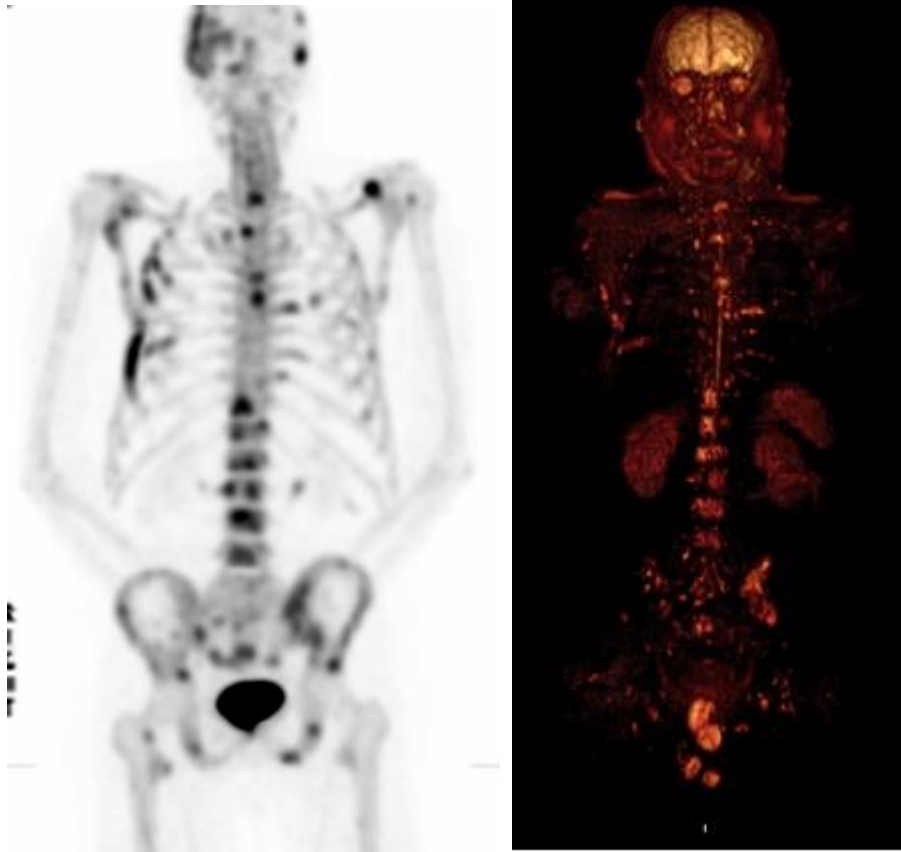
(Left) ^{18}NaF -PET image showing areas of increased tracer activity at metastatic sites involving multiple ribs, spine, pelvis and both scapula. (Right) Colourised maximum projection diffusion-weighted MR image showing good anatomical correspondence of the sites of metastatic bone disease. False negative areas include the skull vault and base, and the anterior ribs. However, normal soft tissue structures such as the brain, kidneys, spleen and testes are also visible on DWI whereas renal excretion is seen on ^{18}NaF -PET.
